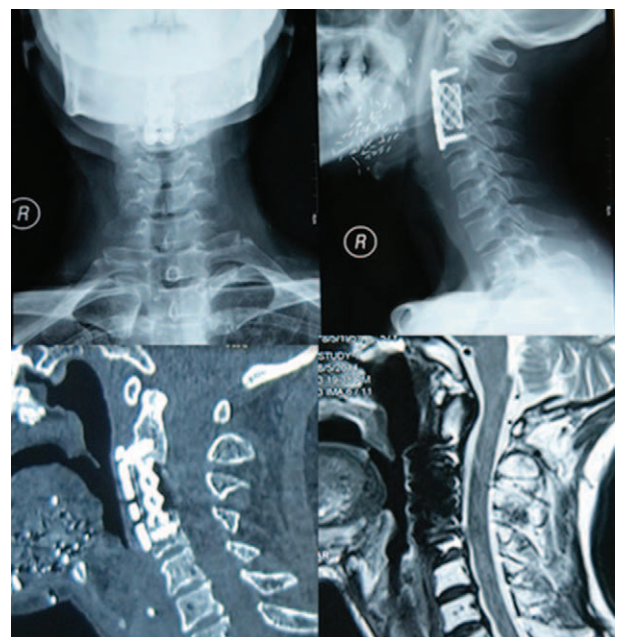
The patient was followed-up with magnetic resonance imaging and computed tomography scans, which did not show any detectable recurrence at 2 months.
